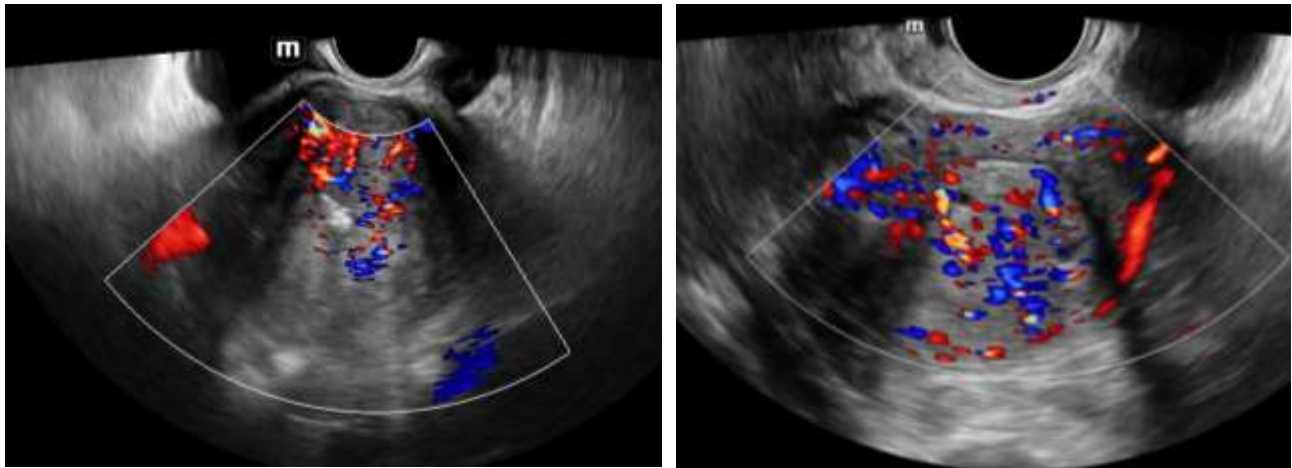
Doppler assessment of endometrial cancer. Severe atypical vascularization
